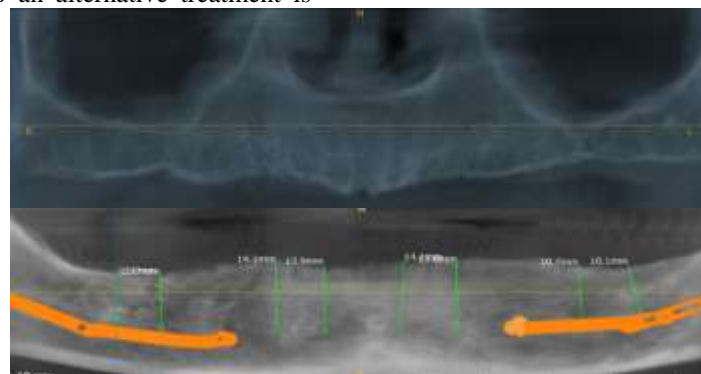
cone beam computed radiography
